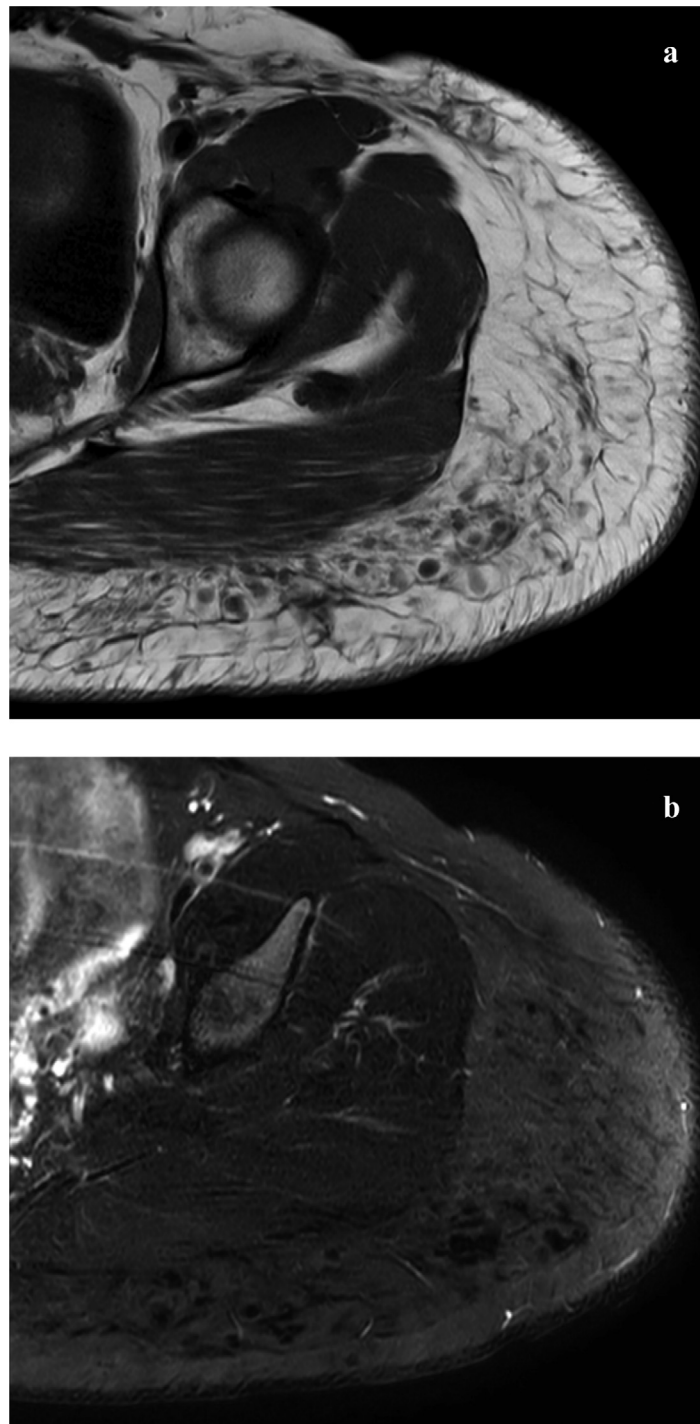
Subsequently obtained (a) T1 and (b) fat-suppressed T2 axial MR images of the left hip/gluteal region demonstrating the site of injected foci of subcutaneous liquid silicone as iso-to-hypointense signal on both T1 and T2 sequences.
